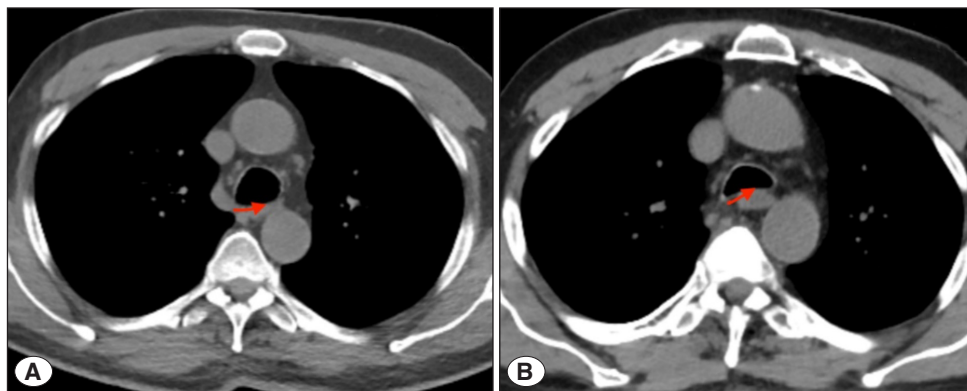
A) A mild collapse in the distal tracheal lumen on the thoracic CT scan performed 2 years ago (signed with red arrow). B) Progressed collapse in the distal tracheal lumen on the thoracic CT scan taken after radiotherapy (signed with red arrow).
